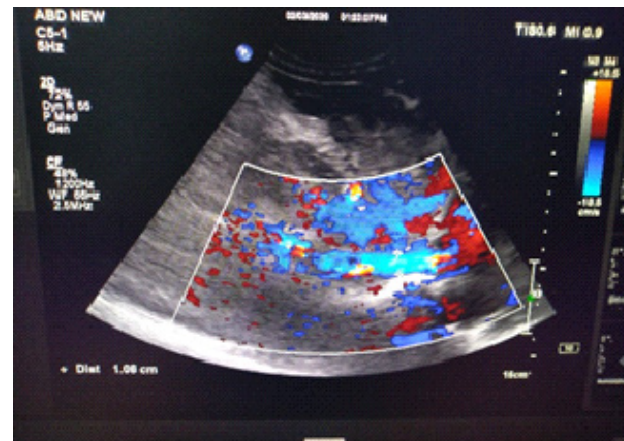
Doppler USG (no thrombus after rivaroxaban)
